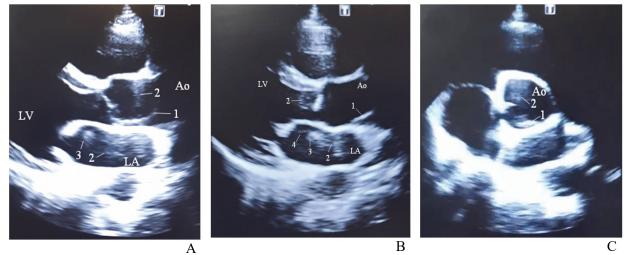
EchoCG of the patient: A, B – Parasternal long axis view; C – Apical short axis view; 1 – Lambl's excrescences; 2 – phenomena of spontaneous echocardiographic contrast; 3 – microthrombus; 4 – thread of thrombus; LV – left ventricle, LA – left atrium, Ao – aorta.
